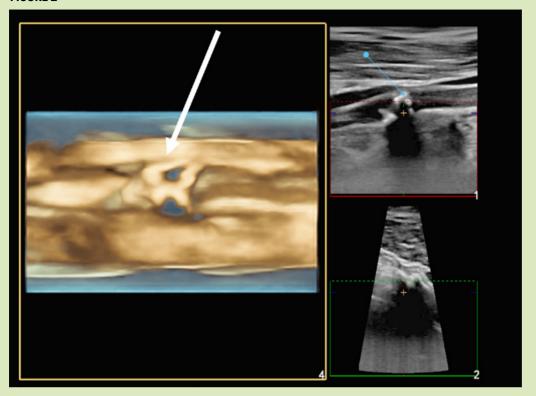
shows some examples of pathologic atherosclerotic plaque in the carotid artery obtained from our echocardiography lab at the University of Colorado. What can be appreciated is the entire depth and total volume of the plaque. Quantification of vessel wall volume and vessel plaque volume is accomplished using Q lab software. As shown, the vessel wall volume coupled with carotid plaque volume is a much more quantitative way of summarizing the degree of atherosclerosis, compared with carotid IMT alone. It would be expected that volumetric assessment would be superior to a 2D only evaluation.
